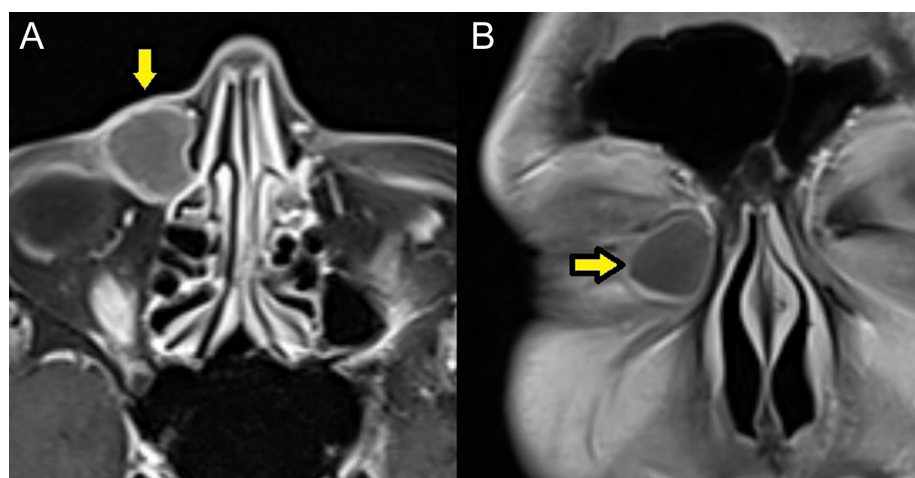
Axial and coronal plane enhanced T1-weighted images indicate the lesion with peripheral enhancement.
